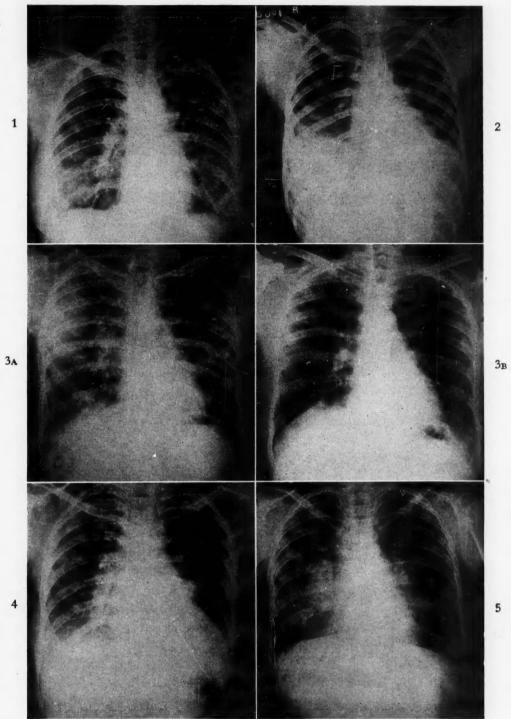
Case I. X-ray of M. B.; pulmonary granulomatosis; exposure to beryllium.
